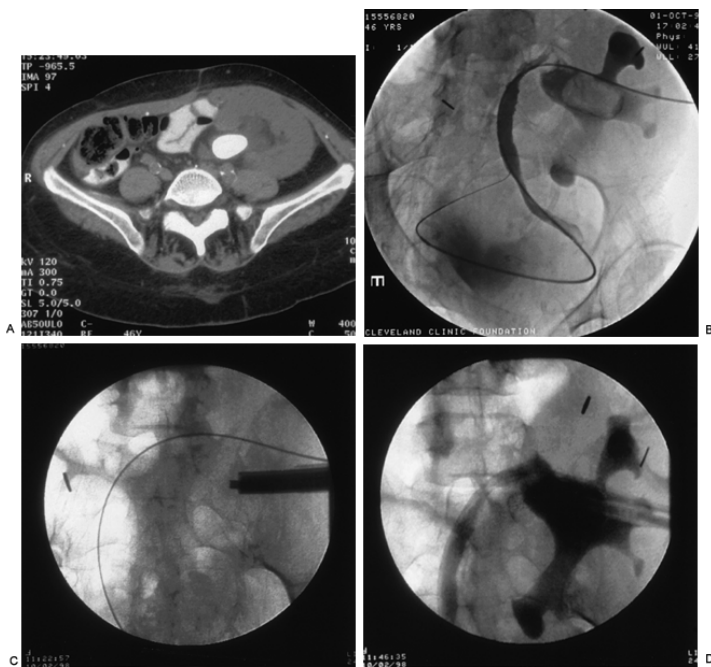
A: Computed tomography scan without contrast in this combined pancreas-kidney transplant patient reveals a large stone in the transplant renal pelvis on the left side. B: Percutaneous access is straightforward, although the patient is in the supine rather than prone position. C: As for native kidneys, rigid nephroscopy with ultrasonic fragmentation and suction is generally the preferred form of management. D: Follow-up nephrostogram shows resolution of the stone without any obstruction or extravasation.
